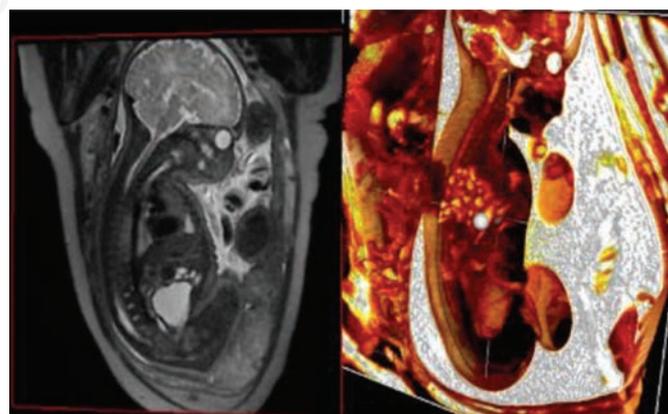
Fetal MRI and its 3-dimensional reconstruction by VR-Render.
